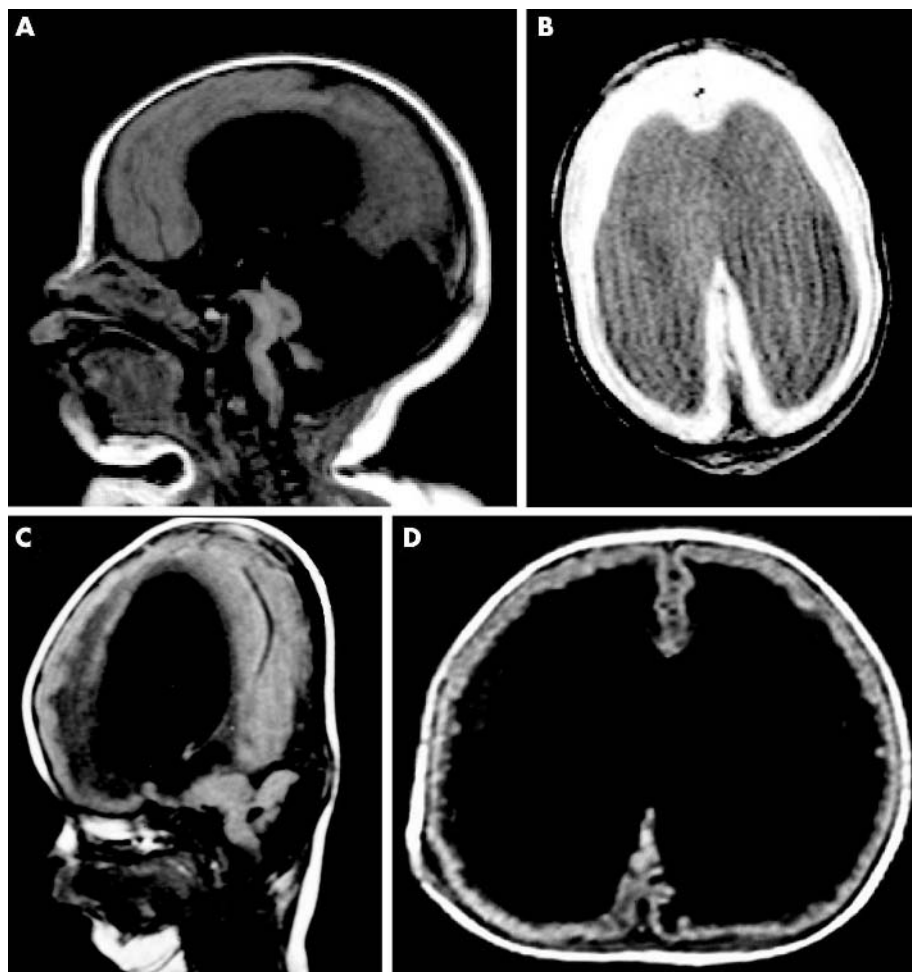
Brain magnetic resonance imaging of patient 1 at two days of age (A and B) and patient 2 at 16 months of age (C and D). Both patients show hydrocephalus, dilatation of the ventricles, agyria, cerebellar hypoplasia, and absence of the corpus callosum.
